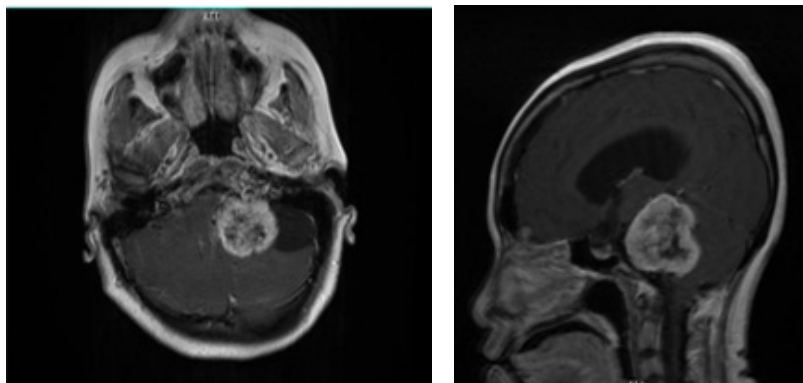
CPA Mass in Magnetic Resonance Imaging, (A) Axial View, (B) Sagittal View
